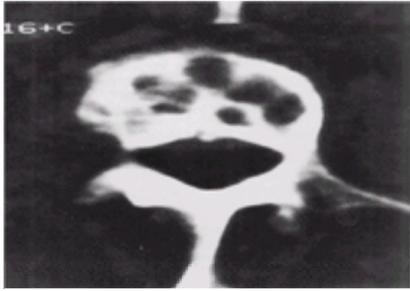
CT scan through the vertebral end plate of a patient with brucellar spondylitis, showing erosive lesions.
